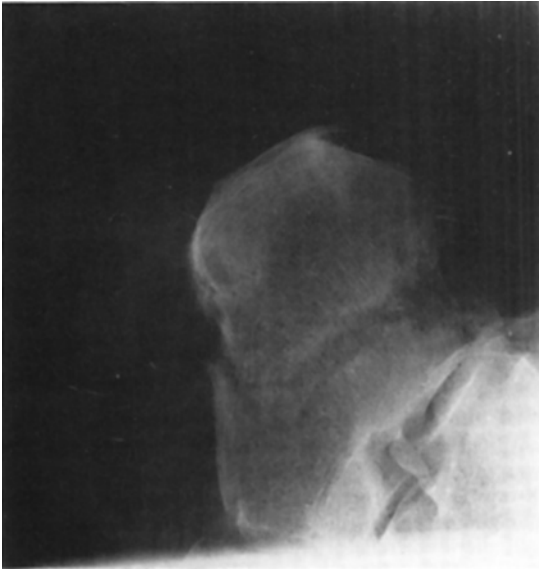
Lateral radiograph of the calcaneal fracture (1971).
